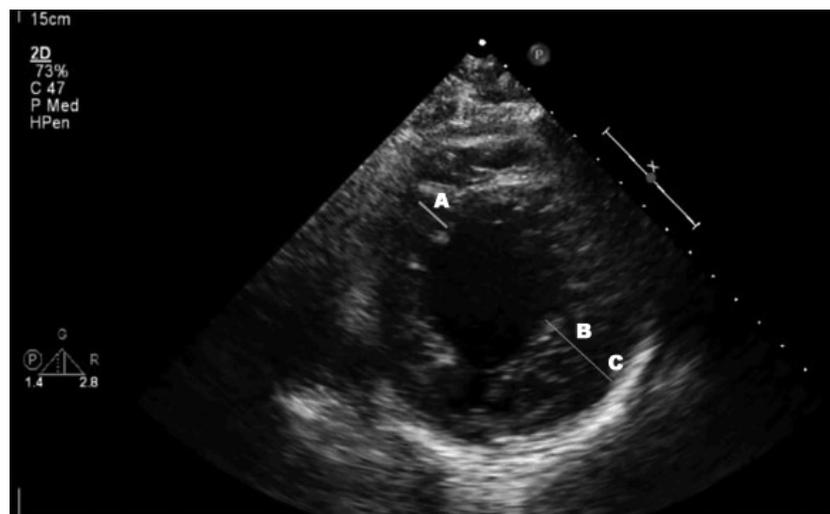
Parasternal short-axis view of transthoracic echocardiogram with measurement of wall thickness showing A) normal nonaffected wall, B) noncompacted subendocardial layer, and C) thinner and compacted subepicardial layer. Ratio of B:A is greater than 2.
